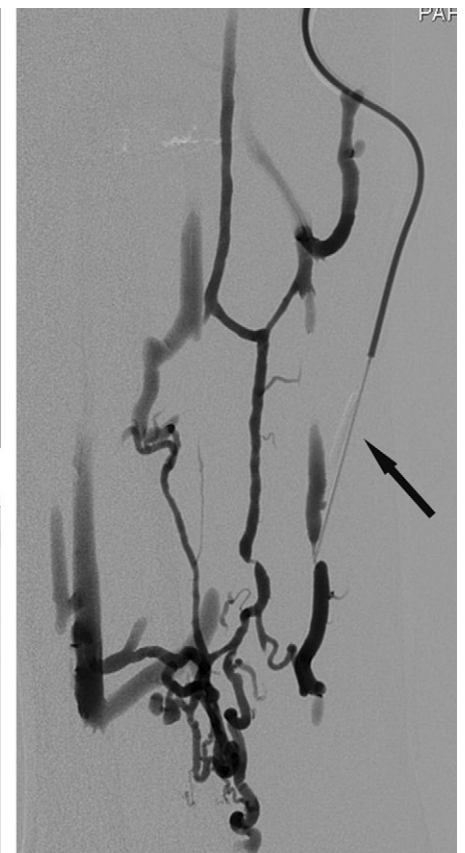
Images in a patient with Klippel-Trénaunay syndrome of the lower limb. After five treatment sessions with foam STS, the patient had a moderate reduction in pain and swelling. (a) Fat-suppressed T2-weighted MR image shows a diffuse malformation involving the medial aspect of the thigh. (b) Digital subtraction venogram obtained after injection of contrast medium via a 21-gauge needle (arrow) shows opacification of the lesions. (c) Digital subtraction venogram obtained after injection of foam STS shows displacement of the iodinated contrast medium by the foam STS. Arrow indicates the needle.
